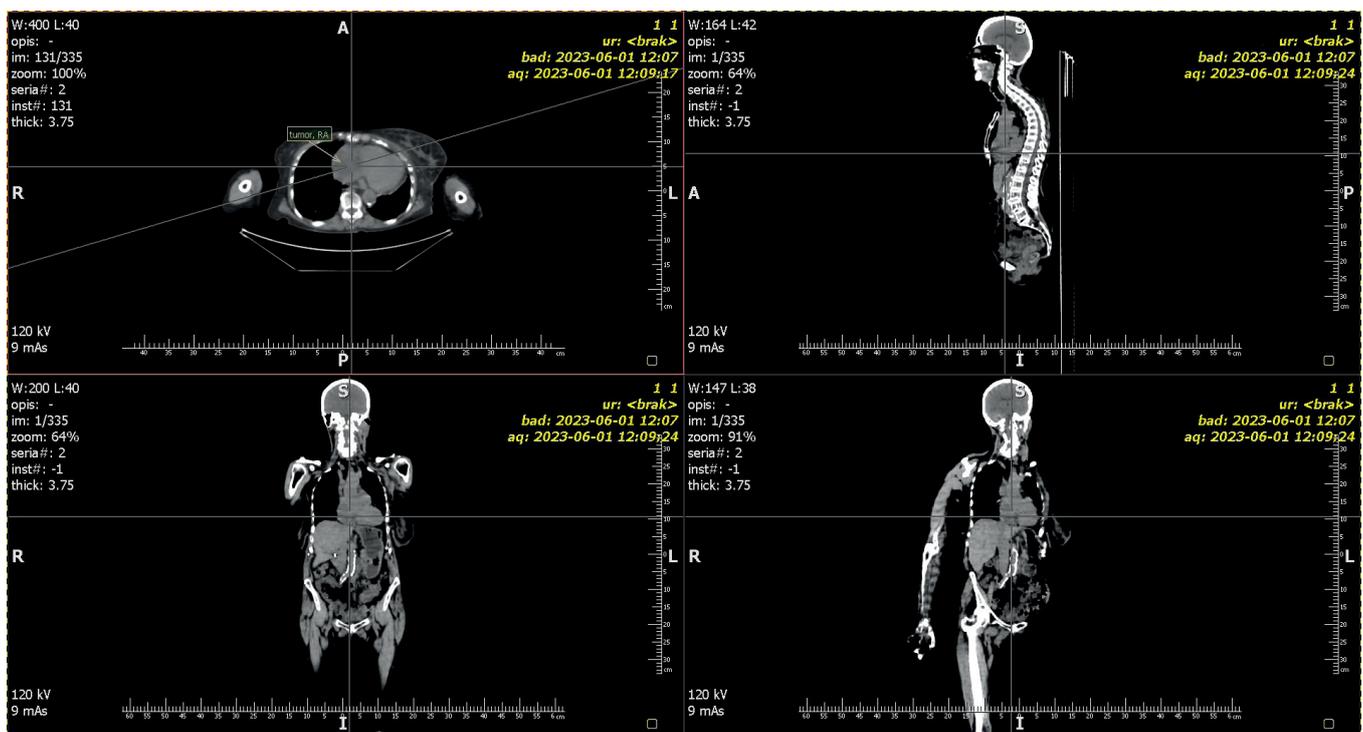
The right atrium tumour of comparable size as noted in transthoracic echocardiogram
